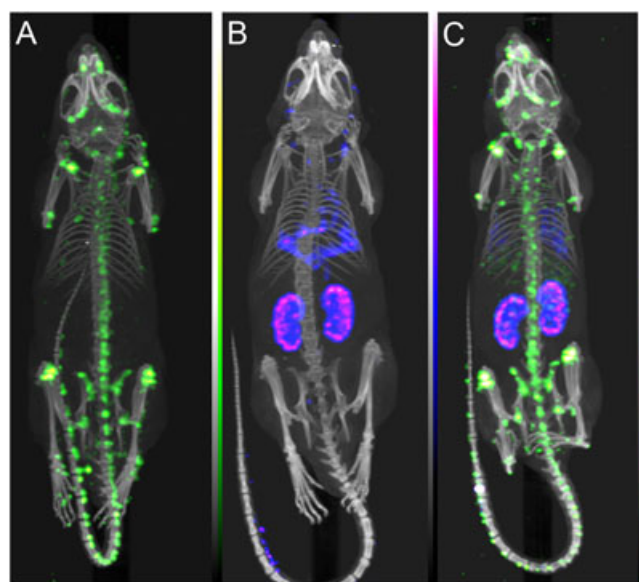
SPECT/CT images of single-isotope acquisition of (a) ^{177}Lu (green), (b) ^{111}In (blue/purple) and (c) dual-isotope simultaneous acquisition of ^{177}Lu (green) and ^{111}In (blue/purple) (all 3 h circulation time).
